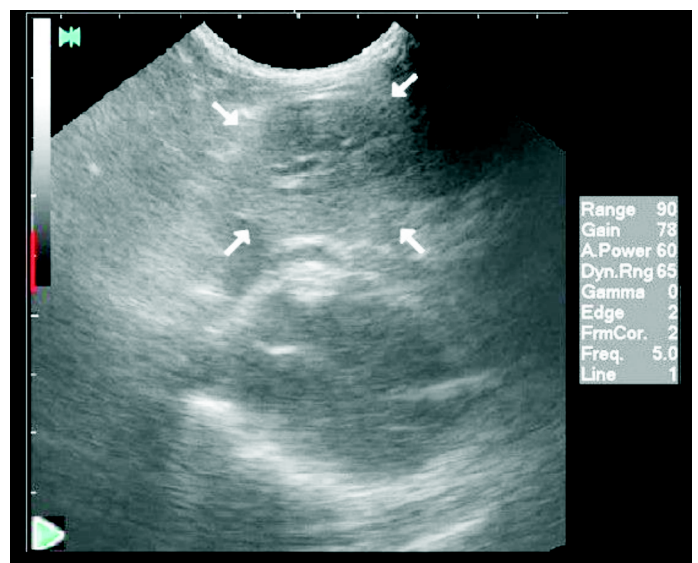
Ultrasonographical image in parasternal projection. At heart atrium height, a portion of the liver visualized in the pericardial sac (arrows)
